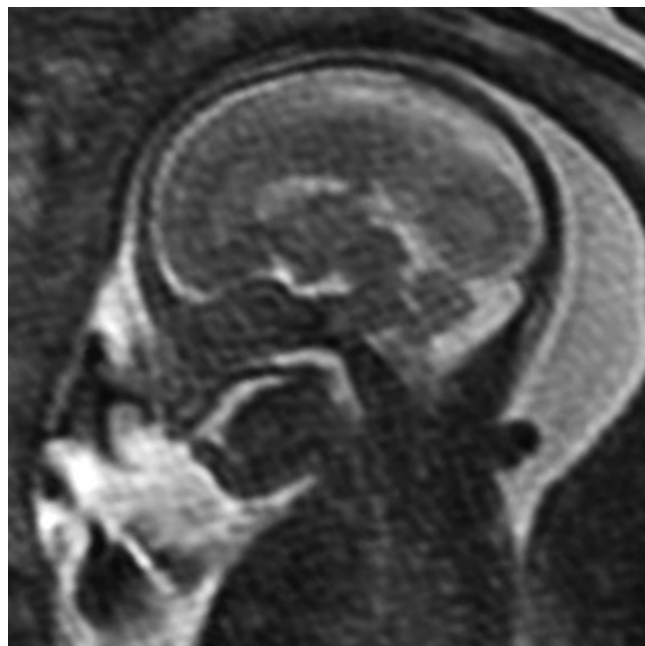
Normal palate. Sagittal T2-weighted ETSE image shows the normal palate extending posteriorly from the frenulum of the upper lip as a continuous T2 hypointense arch, outlined by the normal fluid-filled nasopharynx and oropharynx. The palate continues posteriorly to the nasal choanae, where the nasopharynx and oropharynx meet.
